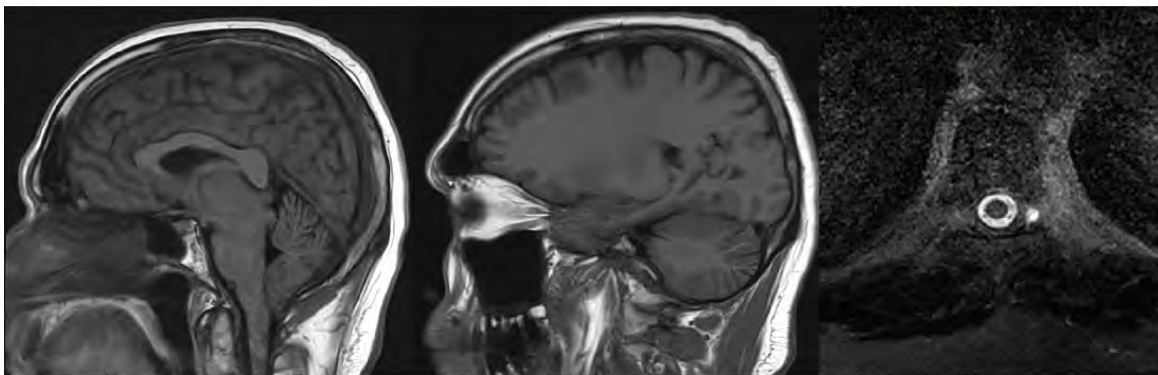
MRI brain (left, middle) demonstrates cerebellar tonsillar descent, and brainstem sagging with decreased mamillopontine distance, decreased prepontine and suprasellar cistern caliber, and possible mildly convex margins of the right transverse sinus. MRI whole spine (right) showed meningeal diverticula, but no spinal longitudinal epidural collection (SLEC).
